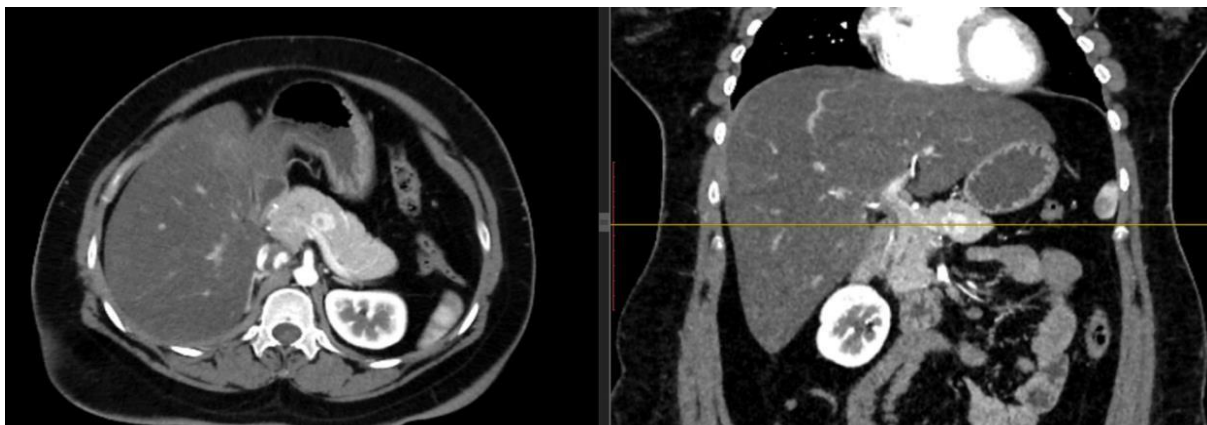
Abdominal CT scan showing presence of tumor at junction of neck and body of pancreas.
